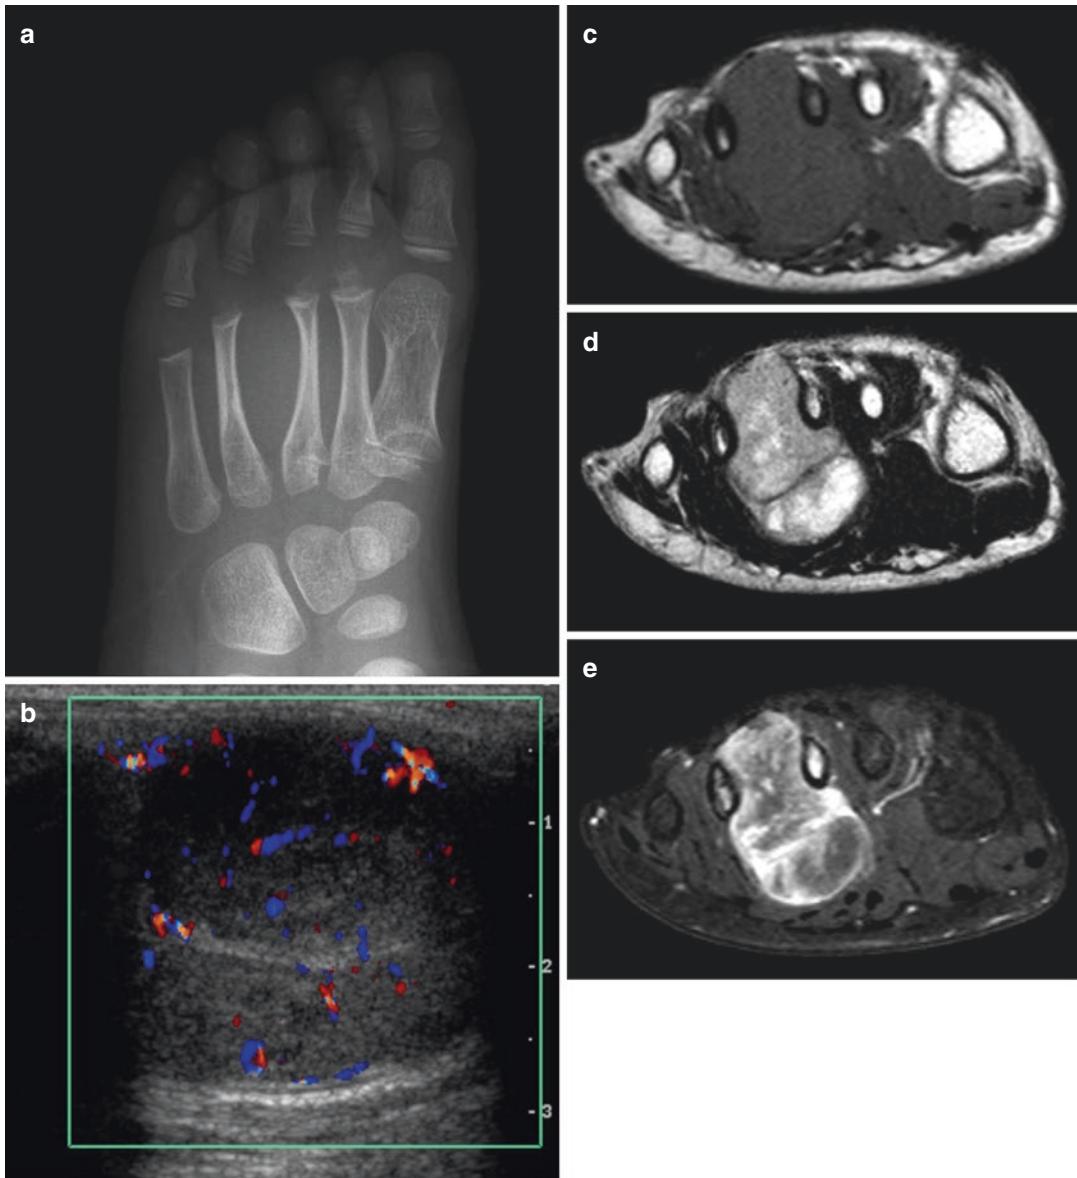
Alveolar rhabdomyosarcoma. Radiograph (a) shows extrinsic scalloping of adjacent metatarsal bones by the soft tissue mass. Color Doppler image (b) reveals a circumscribed, inhomogeneous hypoechoic mass with intralesional hypervascularity and posterior sonic enhancement. The mass located between the metatarsal
